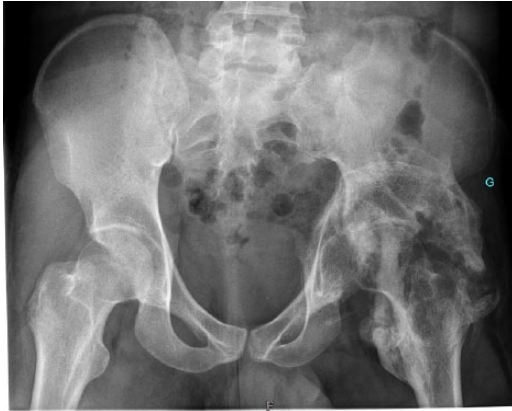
Antero-posterior X-ray both hips showing neurogenic heterotopic ossification around the left hip and femoral head necrosis.
